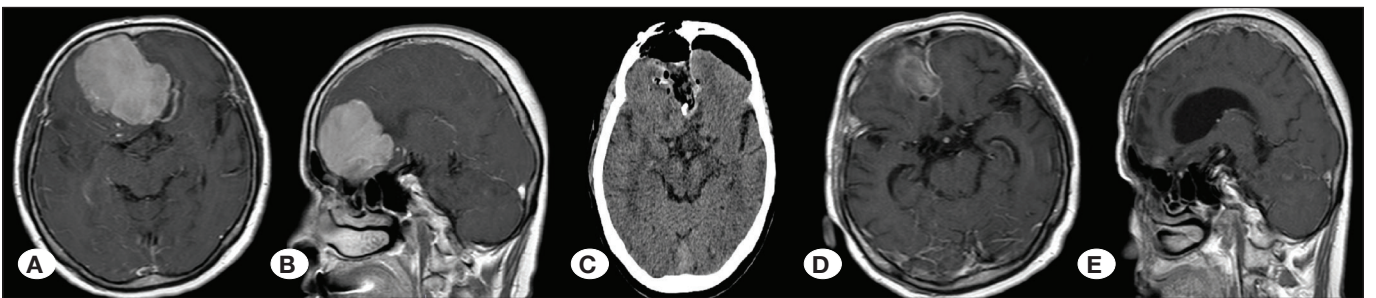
Preoperative axial (A) and sagittal (B) contrast-enhanced T1-weighted MR images show a giant olfactory groove meningioma. C) Postoperative axial computed tomography scan showing total excision of the mass lesion. D, E) Postoperative 3-month follow-up cranial MRI scans confirming total excision of the mass lesion.
